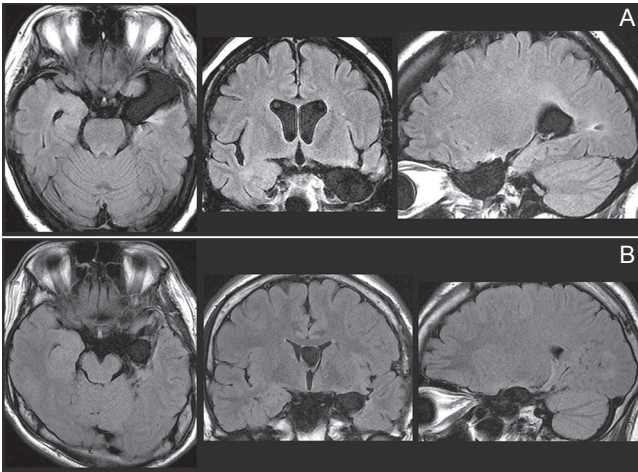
Postoperative magnetic resonance imaging showing the extent of resection after temporal lobe surgery. A: Standard anterior temporal lobectomy and B: selective amygdalohippocampectomy.
